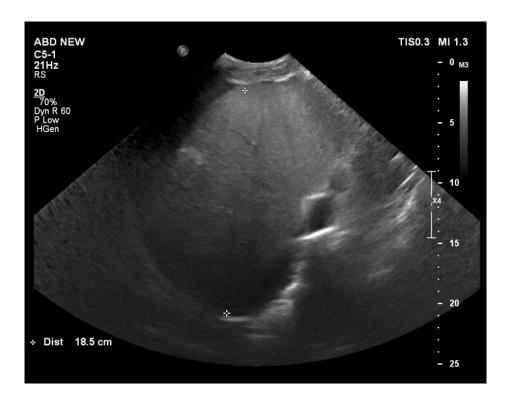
shows 2D greyscale ultrasound image of the liver, demonstrating increased echogenicity with smooth echotexture with increased liver size – suggestive of hepatomegaly with fatty liver.
